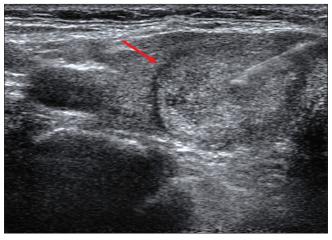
The ultrasound-guided fine-needle aspiration from a hyperechoic solid nodule with a regular margin and a diameter of 17 mm (EU-TIRADS 3), which was proved by cytology to be a nodular goiter. EU-TIRADS: European Thyroid Imaging Reporting and Data System. Red arrow shows the nodule.
